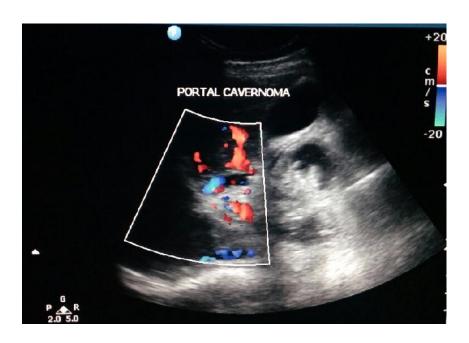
Colour Doppler USG Image showing cavernomatous transformation of portal vein/portal cavernoma
